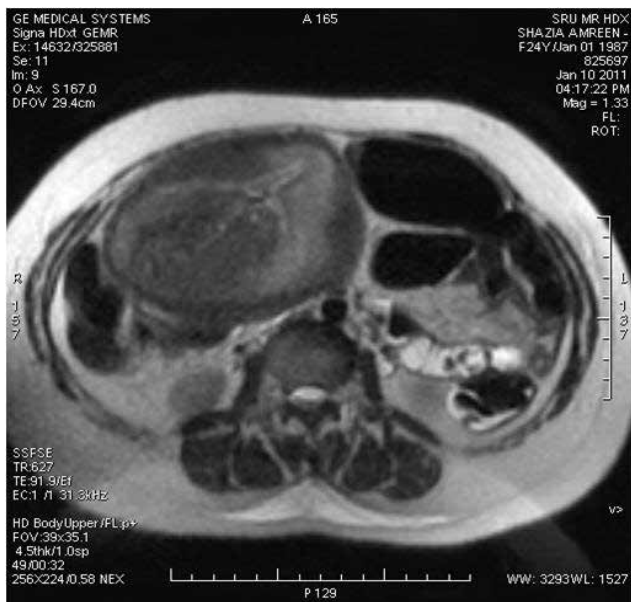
MRI showing placenta increta.
